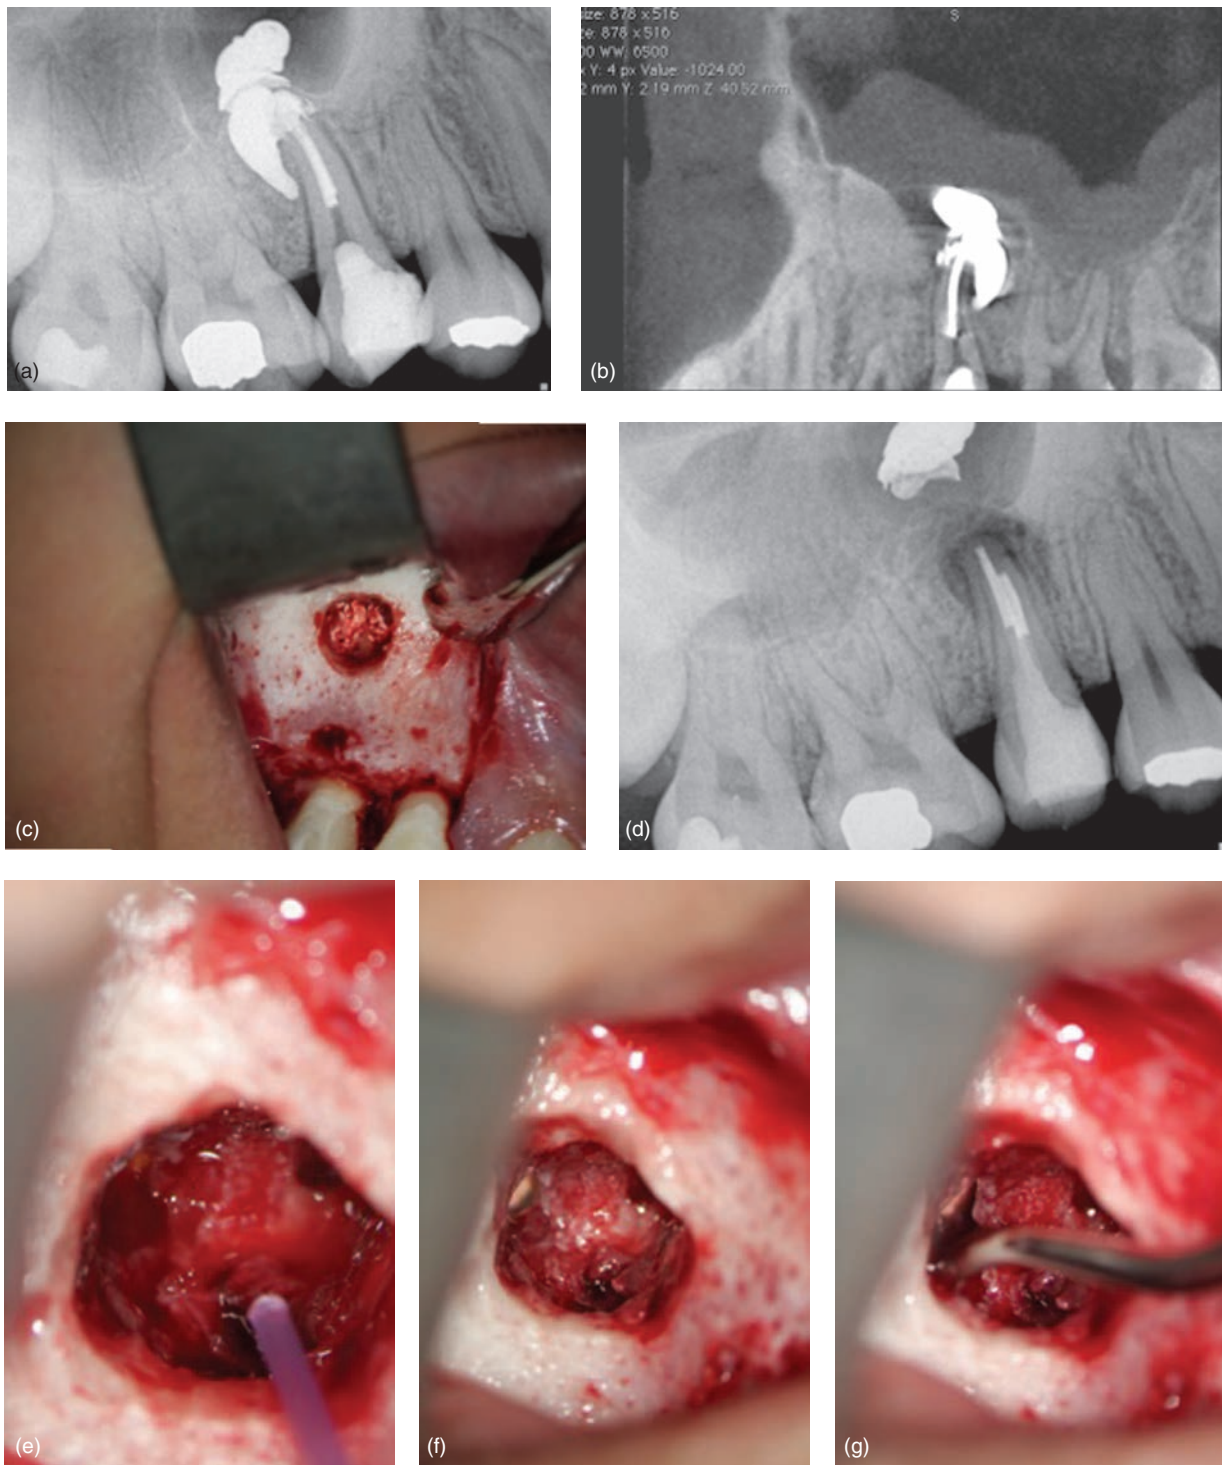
Large overfill of maxillary right second bicuspid with gutta percha in the sinus. Upon applying the surgical approach, part of the gutta percha was removed, dislodging the remainder into the sinus. It was possible to retrieve the remainder of the gutta percha using microsuction and cutting a bigger hole into the sinus and then completing apical retropreparation and root end filling. (a) Maxillary right second premolar with gutta percha overfill. (b) Slice of CBCT showing gutta percha encroaching sinus as well as mucositis of the membrane. (c) After surgical incision and osteotomy, excess gutta percha is observed. (d) Upon attempting to retrieve excess gutta percha, a piece separated and went into sinus. (e) Microsuction tip placed into sinus to retrieve gutta percha (f) Gutta percha seen in upper left corner of sinus (g) Back of spoon used to make hole into sinus larger in order to be able to fit the instrument inside to retrieve gutta percha.
